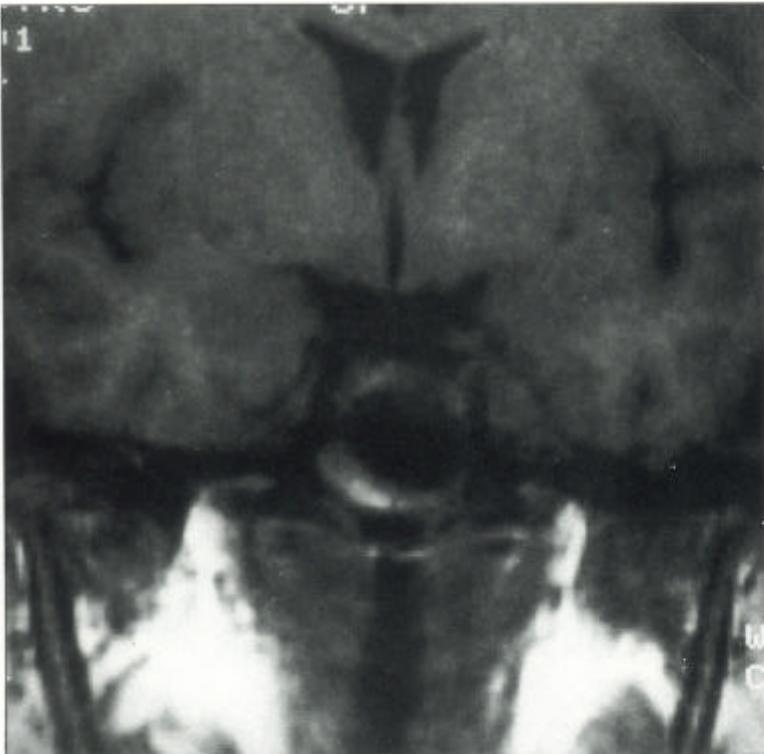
Intravenous gadolinium shows breakdown of the blood-brain barrier in MRI in a way analogous to contrast medium with CT scanning. It is particularly useful in assessing the extent of a lesion. These slides show a meningioma invading the cavernous (top) sinus which enhances markedly after gadolinium (bottom).
